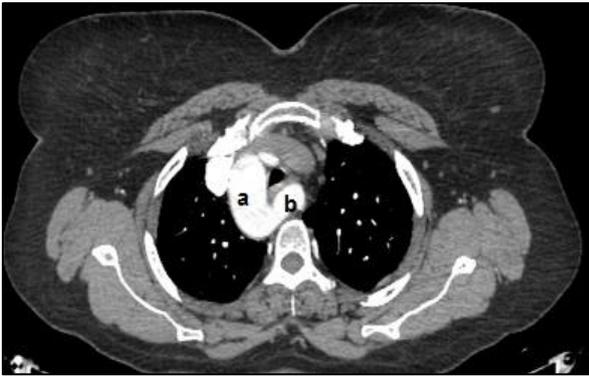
Contrast enhanced computed tomography (CECT) image showing a right sided aortic arch with an Aberrant left subclavian artery noted arising from posterior aspect of the arch as its last branch and crossing the midline (a-aorta, b- aberrant left subclavian artery).
